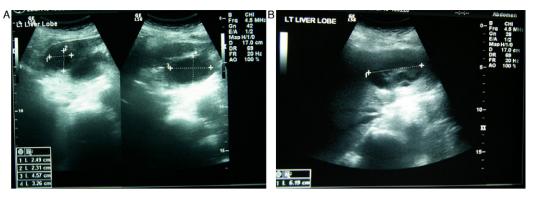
Abdominal ultrasound shows multiple hypoechoic cavities with diaphragms at the left liver lobe.
